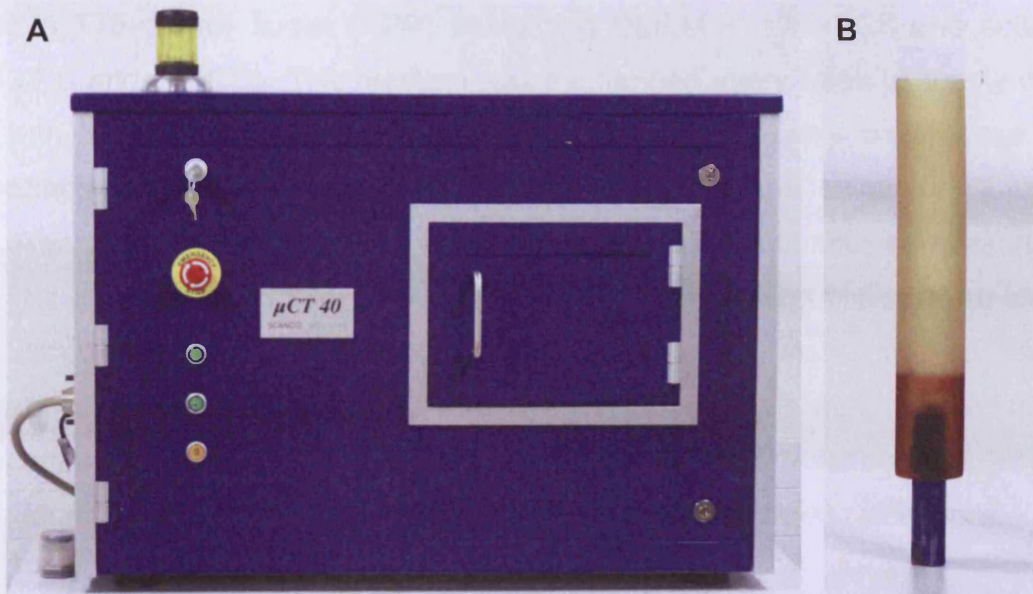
Images of the μ CT 40 device (A) and the μ CT sample holder into which the bone explants were inserted (B).
